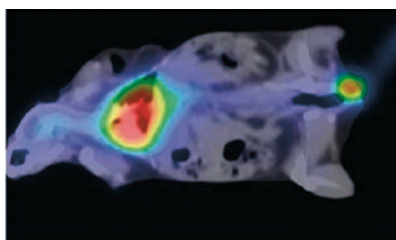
Lung tumour lesion detected by PET/CT using ¹¹C-labeled lung cancer aptamer.
